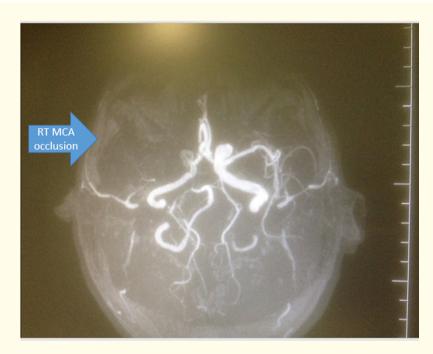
CT cerebral angiography of the same patient revealing complete RT MCA occlusion.
